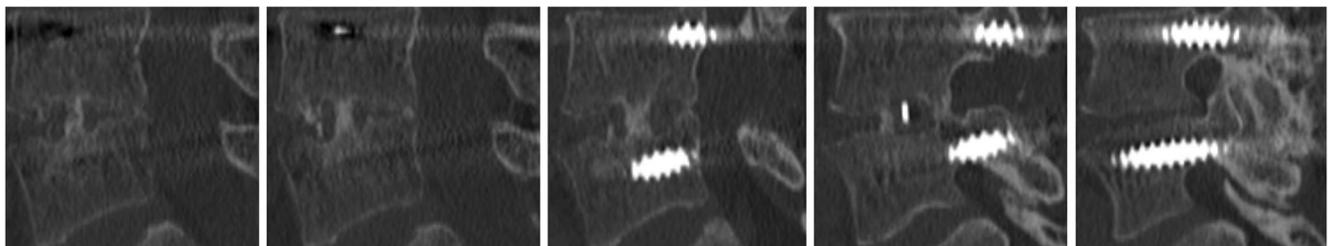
Computed tomography scan images at 2 years after surgery
